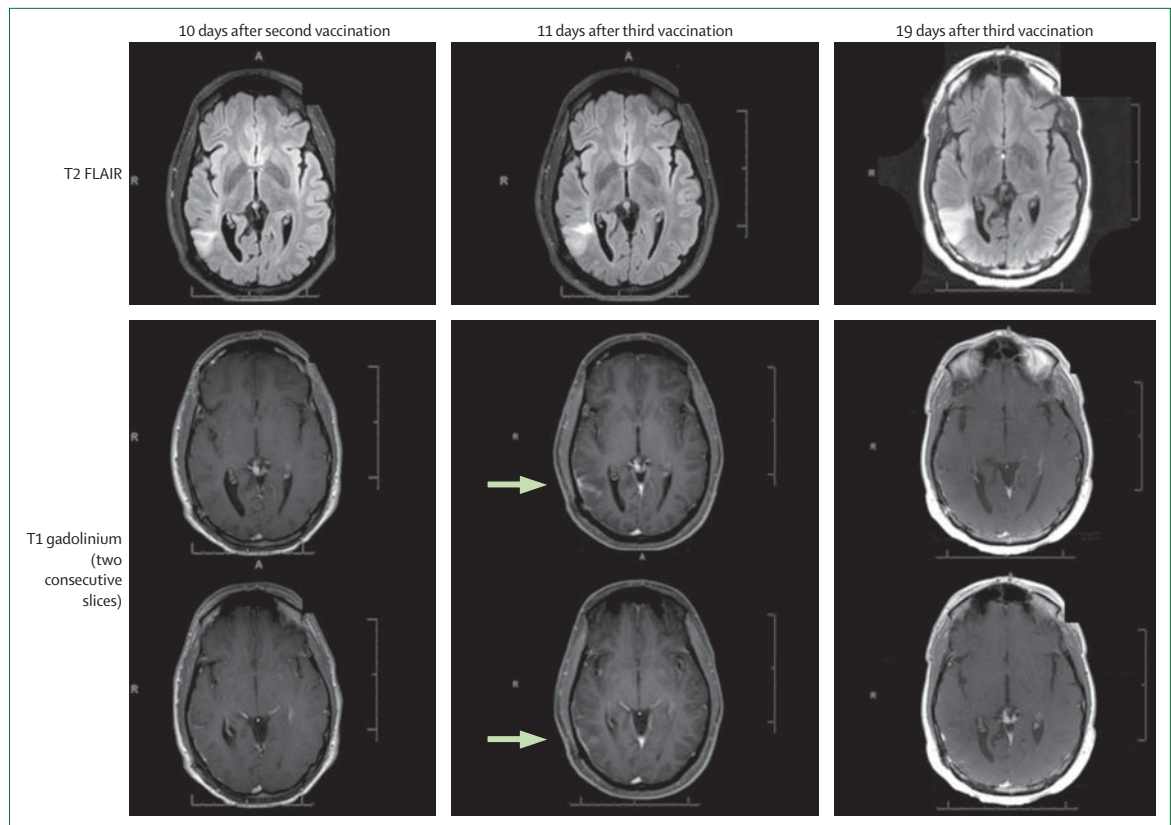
Axial T2 FLAIR and T1 gadolinium-enhanced images obtained after second vaccination (left), at 11 days after third vaccination (middle), and 19 days after third vaccination (right) in a patient with recurrent WHO grade 2 oligodendroglioma (NCT01678352)
